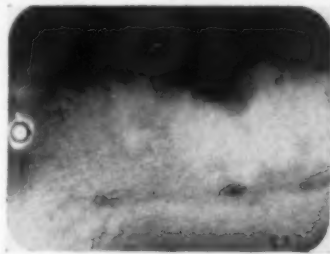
Case 2. Periapical film of the left mandibular premolar region revealed a "cotton wool" appearance.
